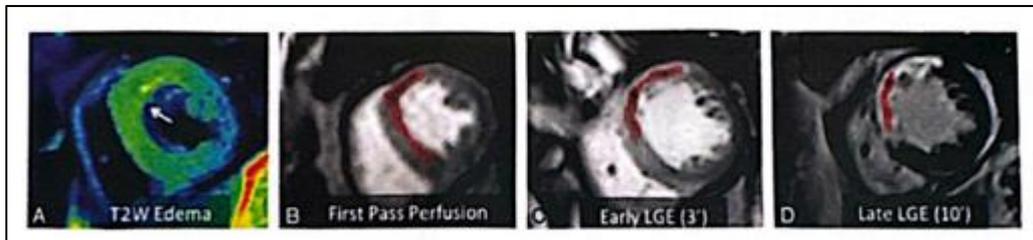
No-reflow phenomenon on cardiac MRI: first-pass perfusion and late gadolinium enhancement [60]
